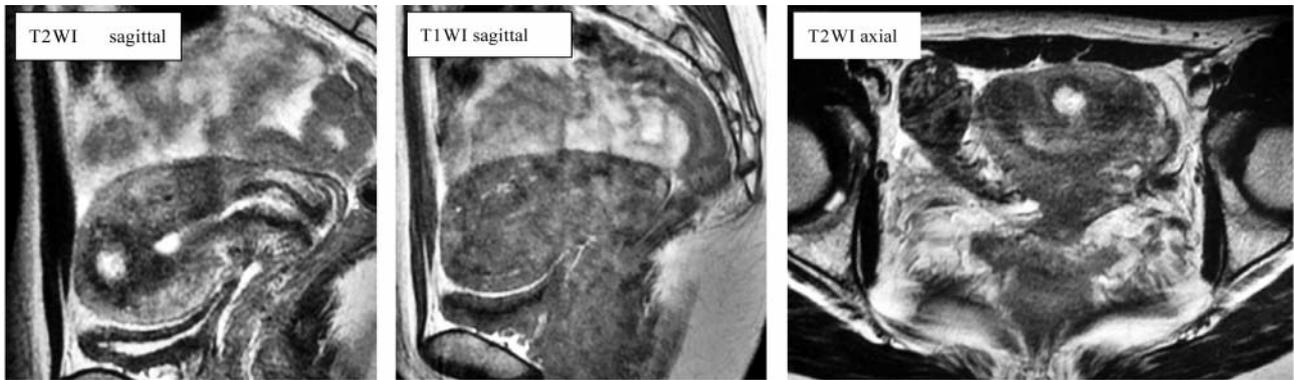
Magnetic resonance imaging revealing a mass with low intensity on T1-weighted images and high intensity on T2-weighted images compared to the myometrium.
